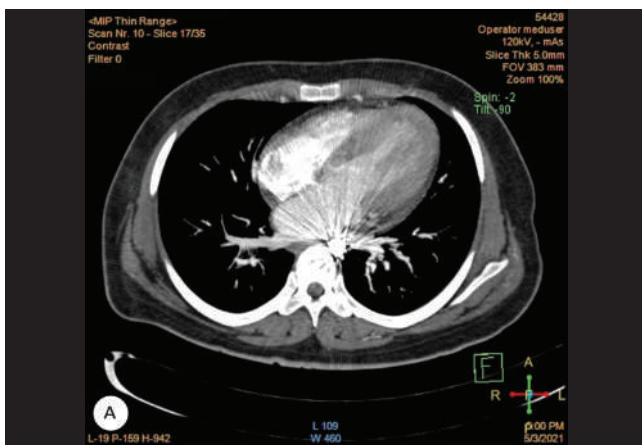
The image presents the computed tomographic angiography of the patient's aorta. The axial view shows the stent in the descending aorta. The filling defect of the mass inside the stent is not detectable possibly because of the streak artifact of the stent.
